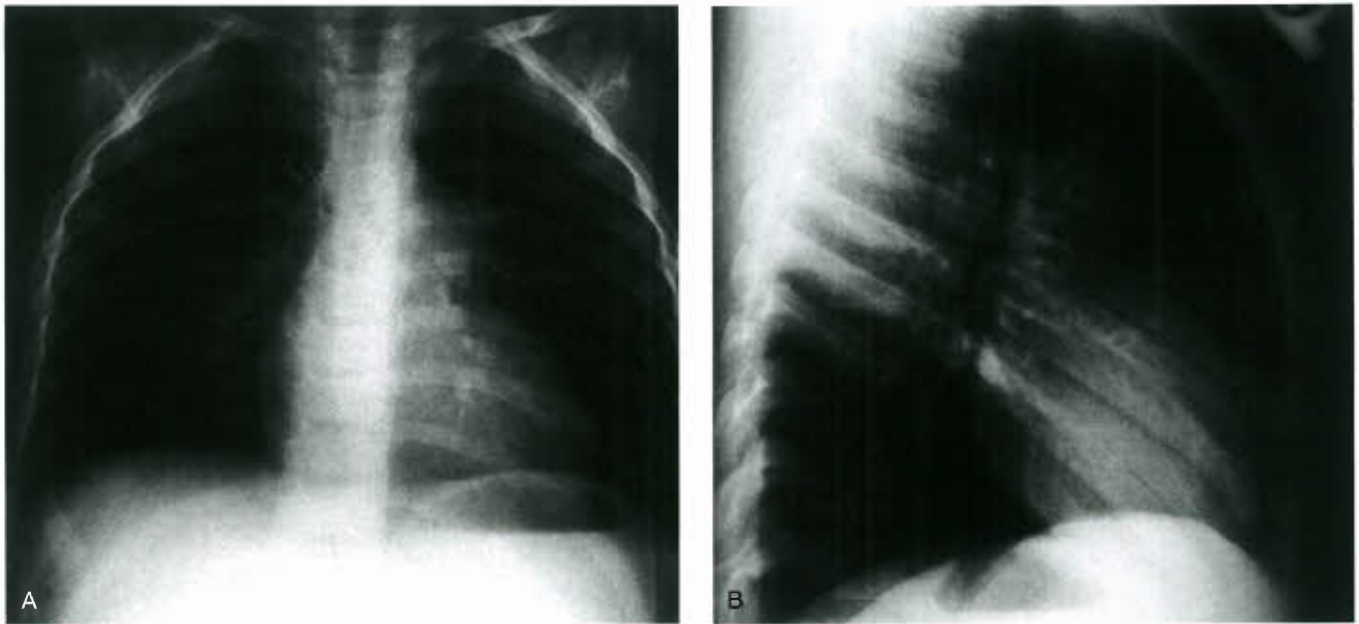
Roentgenogram of a boy with severe valvar pulmonary stenosis and suprasystemic right ventricular pressure. A: Anteroposterior view. Note the prominent right cardiac border and rounded apex pointing downward. The main pulmonary artery segment is dilated. Pulmonary vascularity is normal. B: The lateral view demonstrates prominence of the RV with increased filling of the space between the thoracic wall and anterior border of the heart.
